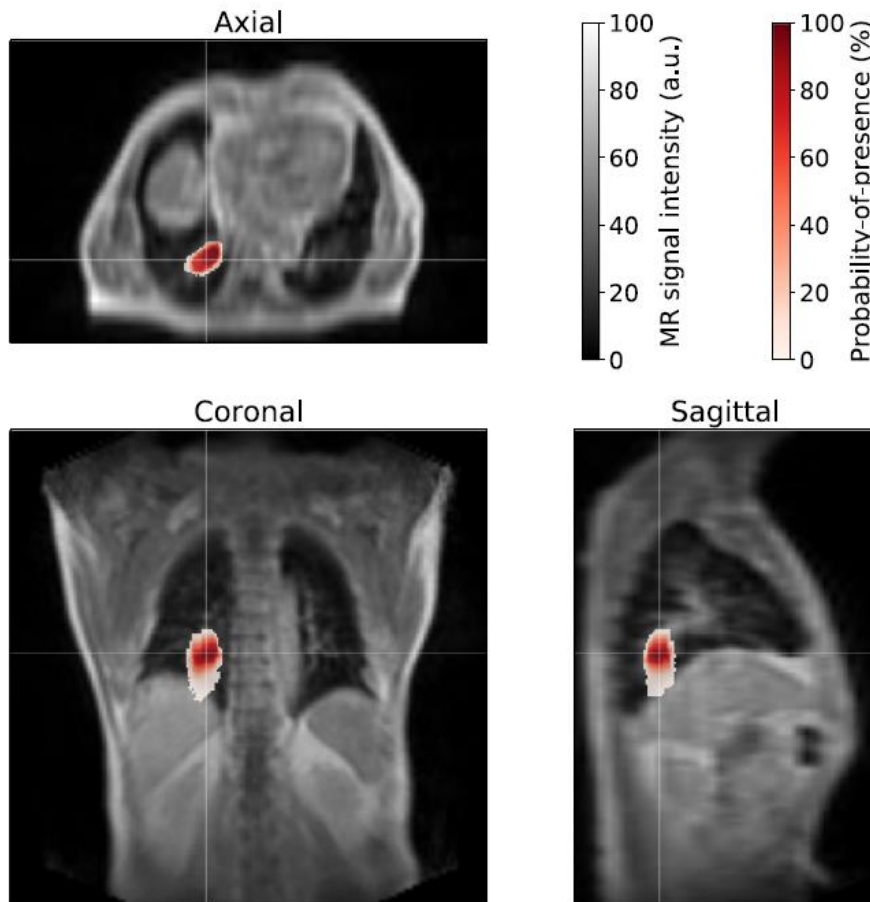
Three-dimensional probability-of-presence (POP) distribution displayed on top of the MR images of an exemplary patient. The POP is color-encoded and superimposed on four-dimensional-magnetic resonance imaging (MRI). The crosshairs indicate the slice positions in the respective axial, coronal, and sagittal views. Figure adapted from [7].
